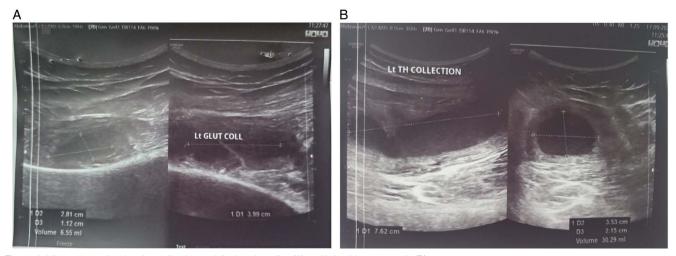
Ultrasonography showing collection on left gluteal medius (A) and left adductor muscle (B).
